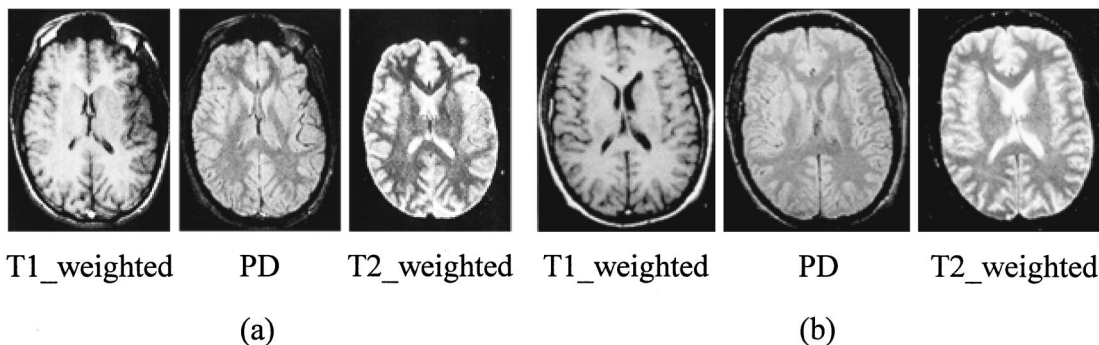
An example of a normal brain MRI: (a) br3 MR images (128×92); (b) br0 MR images (128×94).
